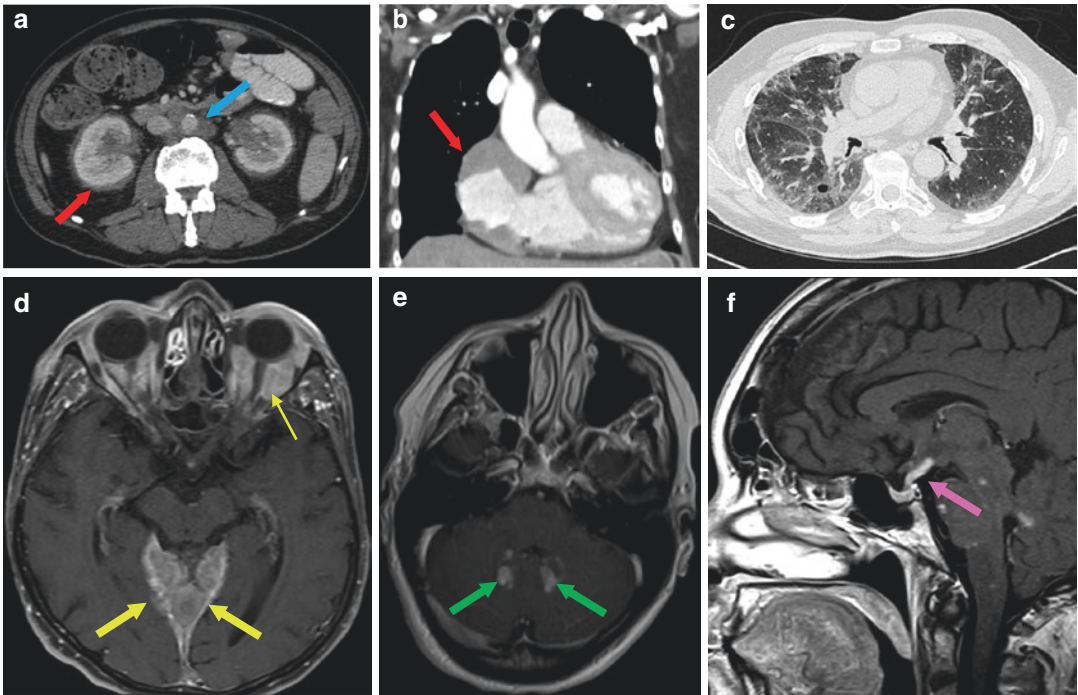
Radiographic findings in common manifestations of Erdheim-Chester disease. (a) Axial CT scan of the abdomen demonstrating dense infiltration of perinephric fat, referred to as a “hairy kidney” appearance (*red arrow*). Circumferential soft-tissue sheathing of the thoracic aorta seen is referred to as a “coated aorta” (*blue arrow*). (b) Coronal CT scan of the chest demonstrates a mass lesion in the right atrium (*red arrow*). (c) Parenchymal pulmonary infiltration on axial chest CT in an ECD patient. (d) Axial post-gadolinium T1 MRI demonstrates expansile
